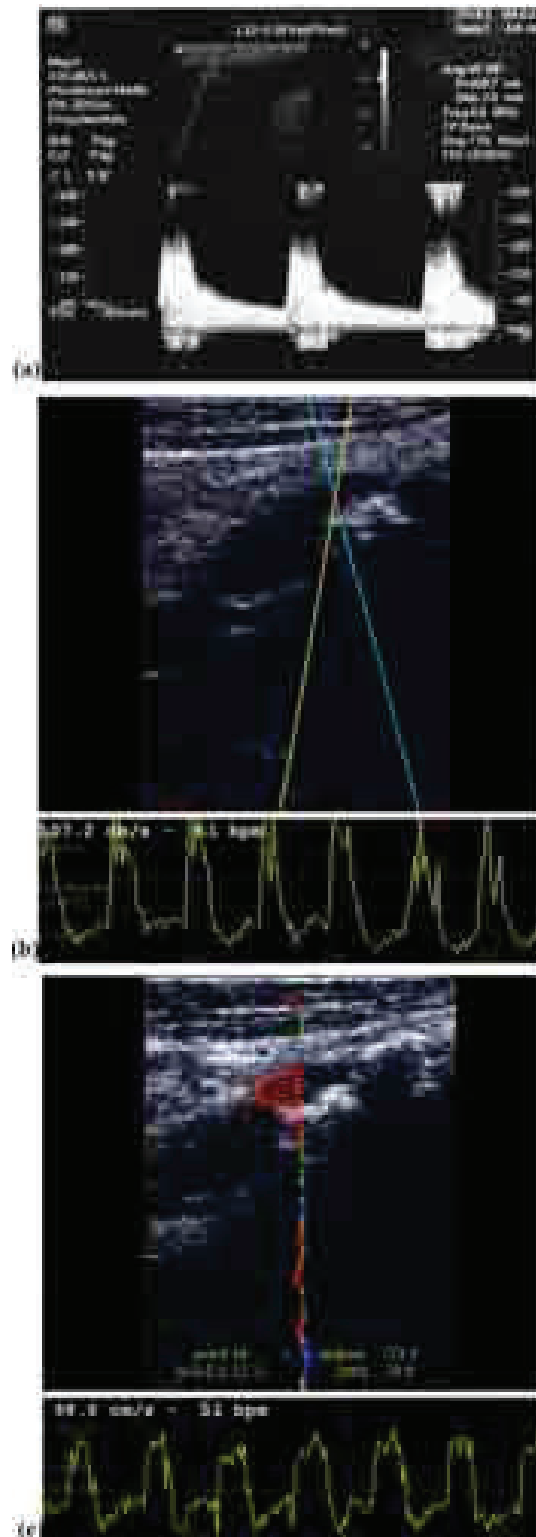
Results of the investigation of a stenosed ICA (70% occlusion) by means of: a) Spectral Doppler; b) Angle Tracking; c) Plane Wave VD methods.
